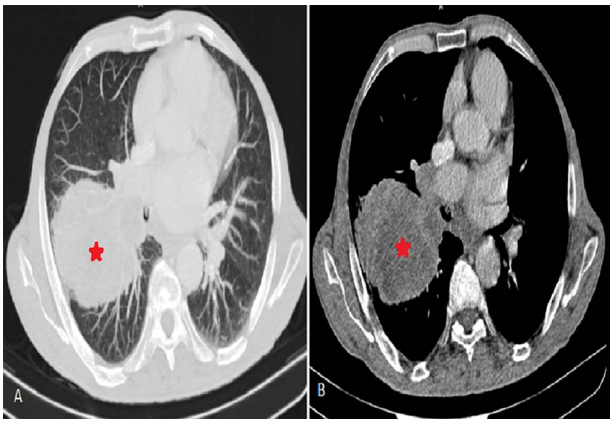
Chest CT scan injected (portal phase) in axial section in a parenchymal (A) and mediastinal (B) window showing a pulmonary mass with a necrotic center highlighted in the periphery in upper right lobe (red star).
